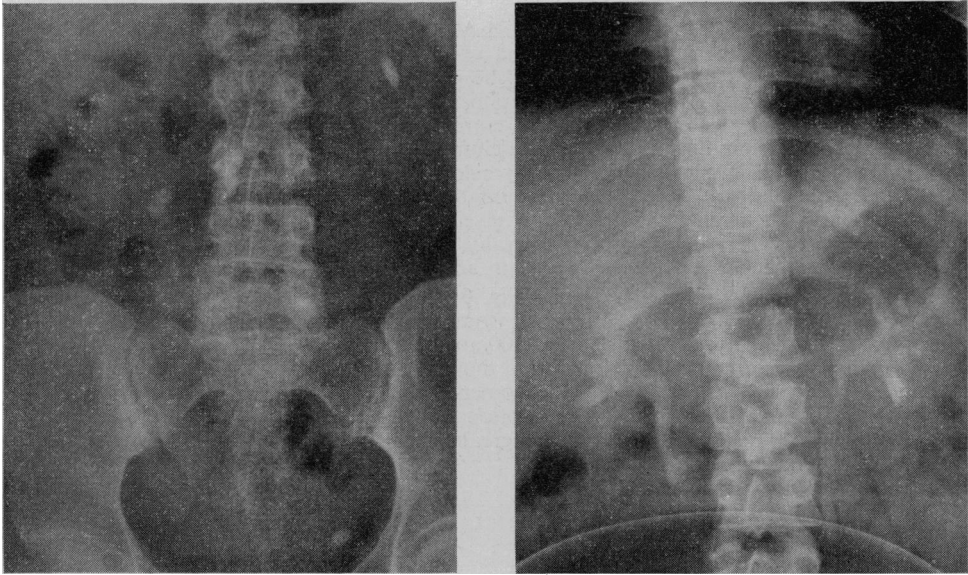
Straight X-ray and intravenous pyelogram of urinary tract of M. G., female, aged 26. There was calculous disease of both kidneys and left pelvic ureter. The urine was infected.
